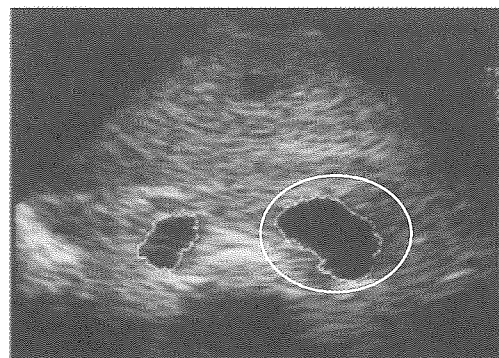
Comparison of the cross sectional area of inferior vena cava between on land condition and in water condition using a B-mode echocardiography. ○: inferior vena cava
